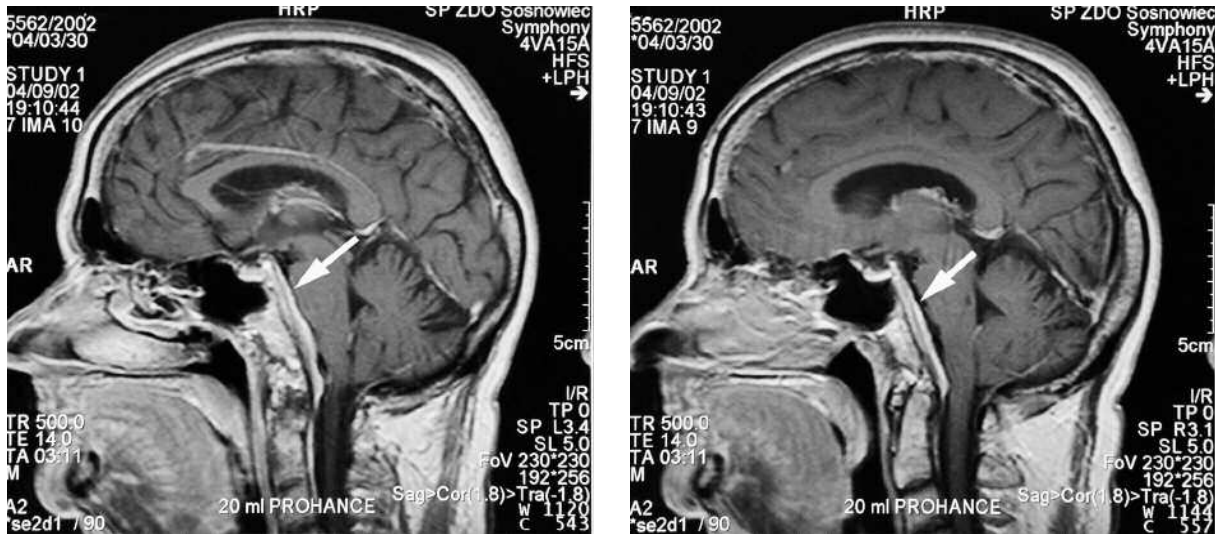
T1-weighted MRI sagittal images with contrast enhancement on admission
